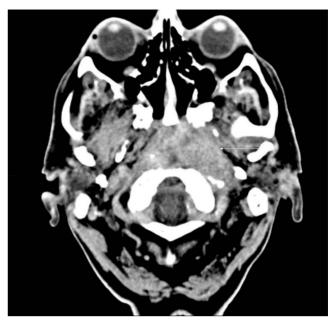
Axial CT showing a midline nasopharyngeal mass, biopsy confirmed non-Hodgkin lymphoma.
